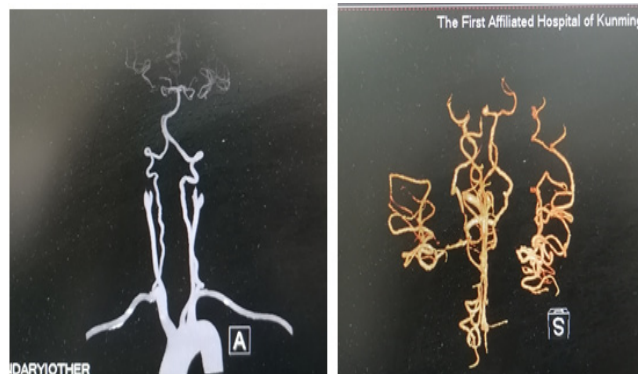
Head and neck CTA.
